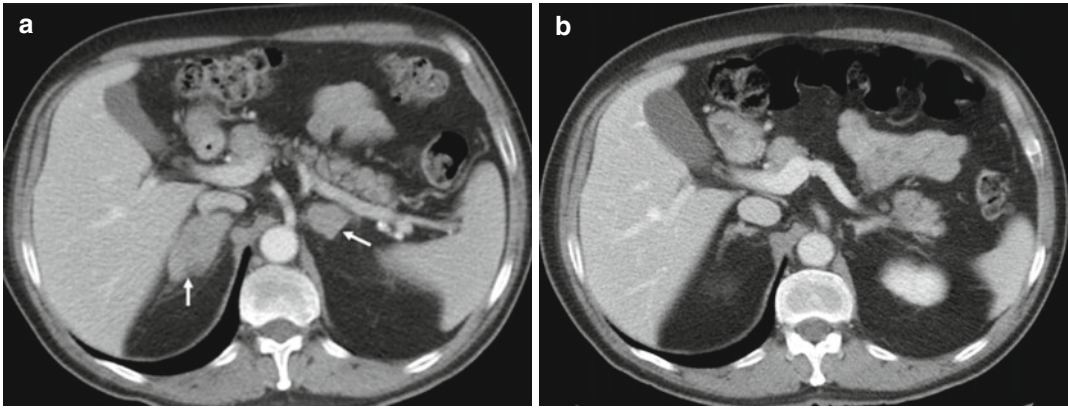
(a) Non-small cell lung carcinoma with adrenal metastases in a 53-year-old man treated with an ALK inhibitor. Pre-therapy (a). CT image shows bilateral
